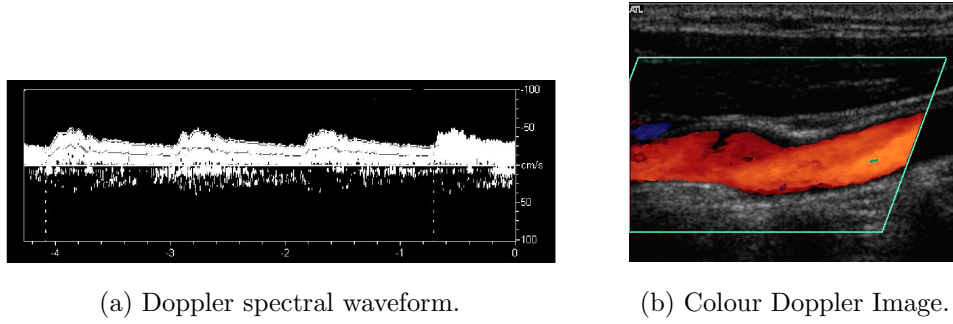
Flow analysis based on the Doppler effect.
